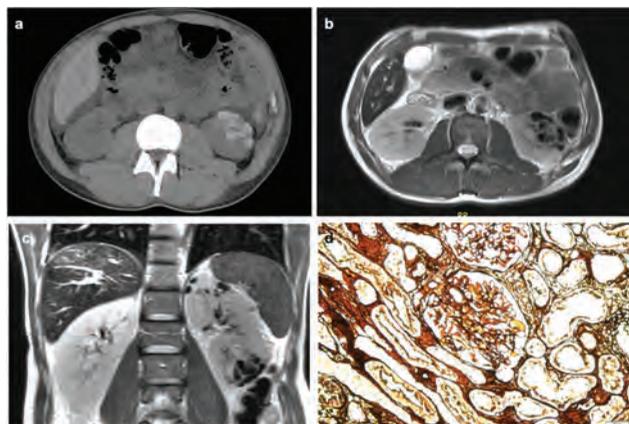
a Hyper-attenuated subcapsular cortical cysts in the left kidney on unenhanced axial CT. Axial (b) and coronal (c) T2-weighted images on MRI show extremely hyperintense cysts, suggesting hemorrhagic content. d Tip lesion variant of FSGS on the right kidney biopsy (PASM; original magnification × 200).
